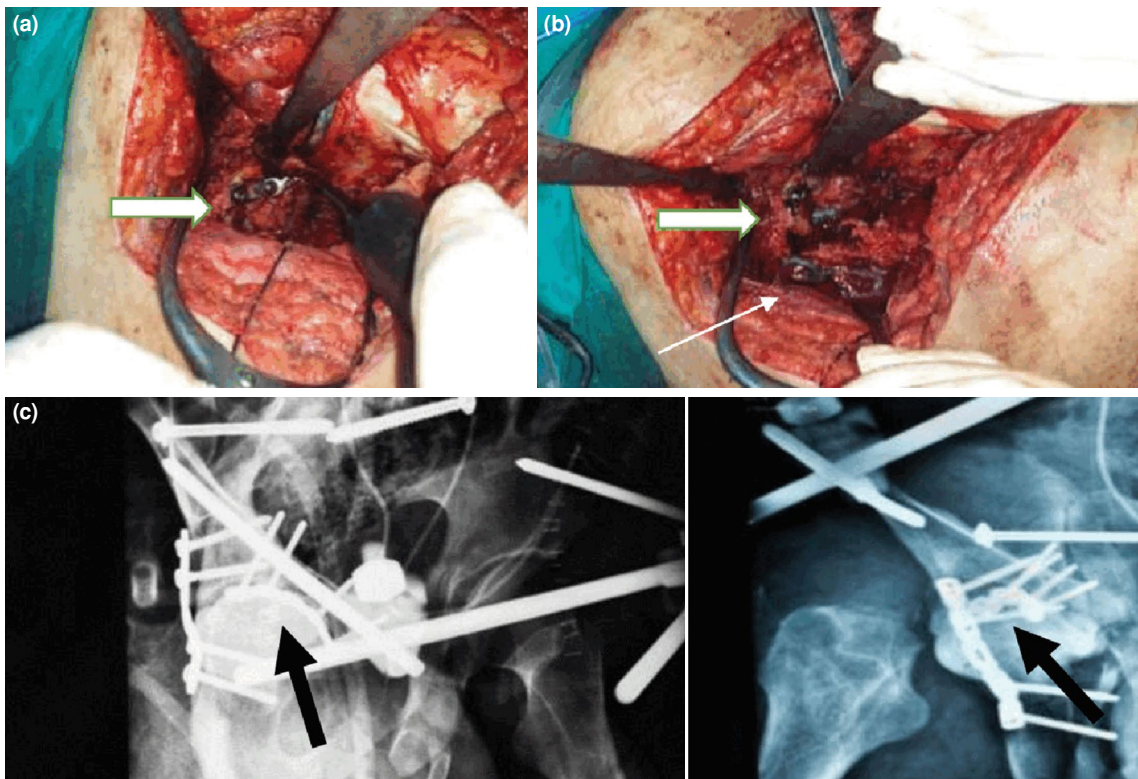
Images of the fixation of the acetabular columns. (a) An intraoperative image showing the intra-articular fixation of the anterior column by 3.5-mm reconstruction plate (thick arrow). (b) An intraoperative image showing the 4.5-mm plate for the posterior column (thin arrow) and the 3.5-mm plate for the anterior column (thick arrow). (c) Postoperative X-ray views after fixation of the acetabular fractures. Black arrow points to the intra-articular plating.
